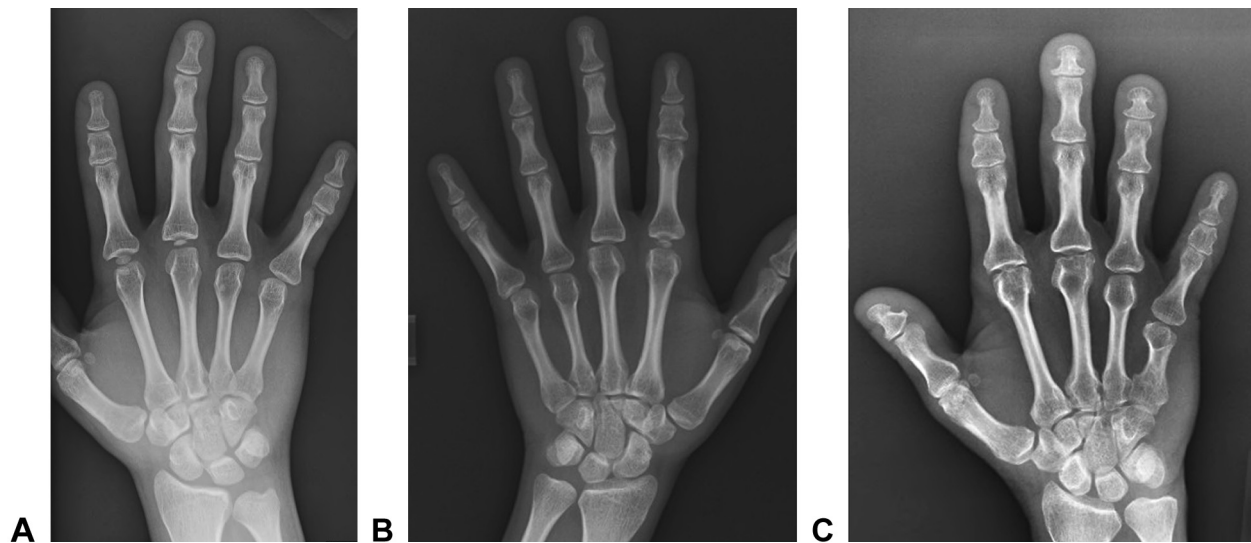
Representative x-rays of the asymptomatic hands of the involved family members. The patient's A, the sister's B, and the mother's C.
